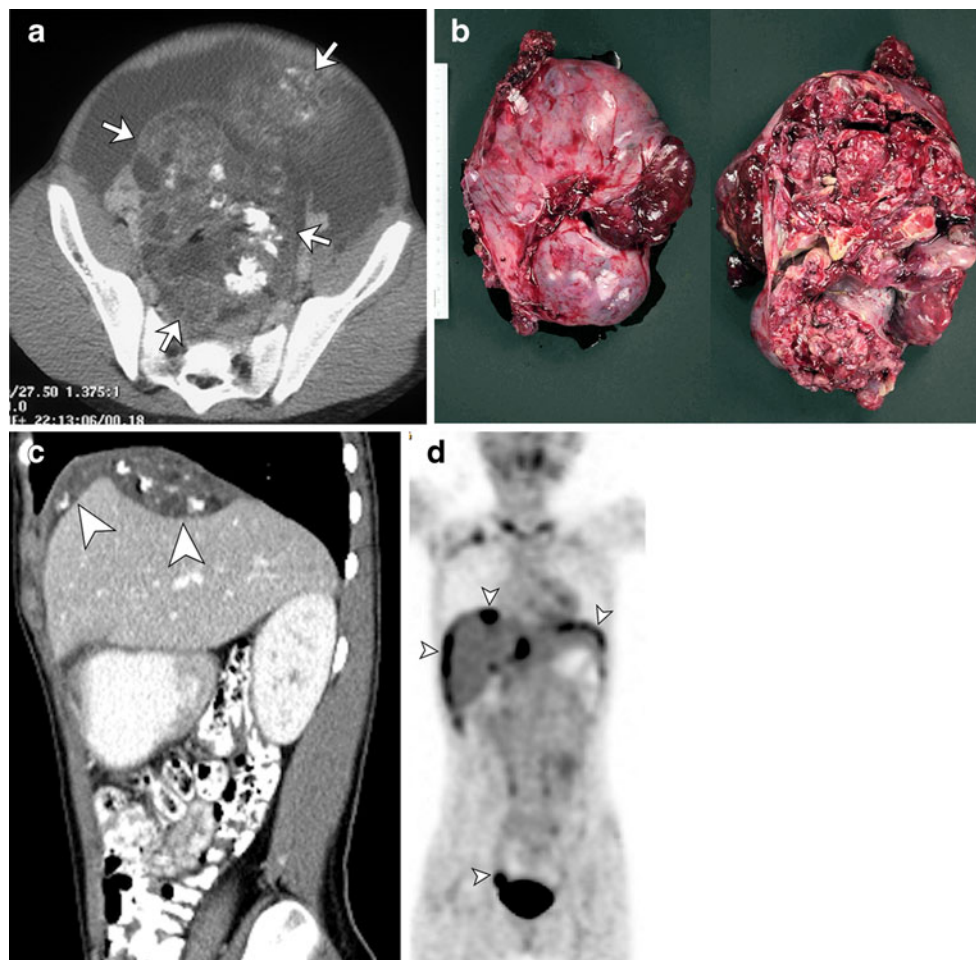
Growing teratoma syndrome in an 11-year-old following bilateral oophorectomies for bilateral, large immature teratomas. a Initial enhanced axial CT scan after a 2-week history of increasing abdominal girth, decreased appetite and fatigue shows large, complex abdominal masses with calcified and scant fatty components. Based on pathology results, it was discovered that she had both immature and mature components of teratoma (*arrows*). Note the large amount of ascites. b Gross pathology images show a large 2,240-gram, 24 × 17 × 13-cm mass with a partially disrupted smooth surface from which hemorrhagic tissue is exuding. The cut surface reveals solid areas composed of soft white-tan to red-tan gelatinous tissue, innumerable small cystic spaces and white-tan calcified areas consistent with bone or dental structures. c Sagittal reformatted CT and (d) coronal PET
